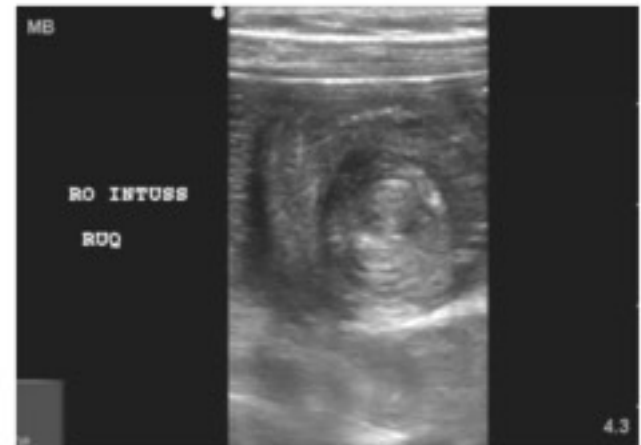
Classic appearance of intussusception on ultrasound "the doughnut sign".
